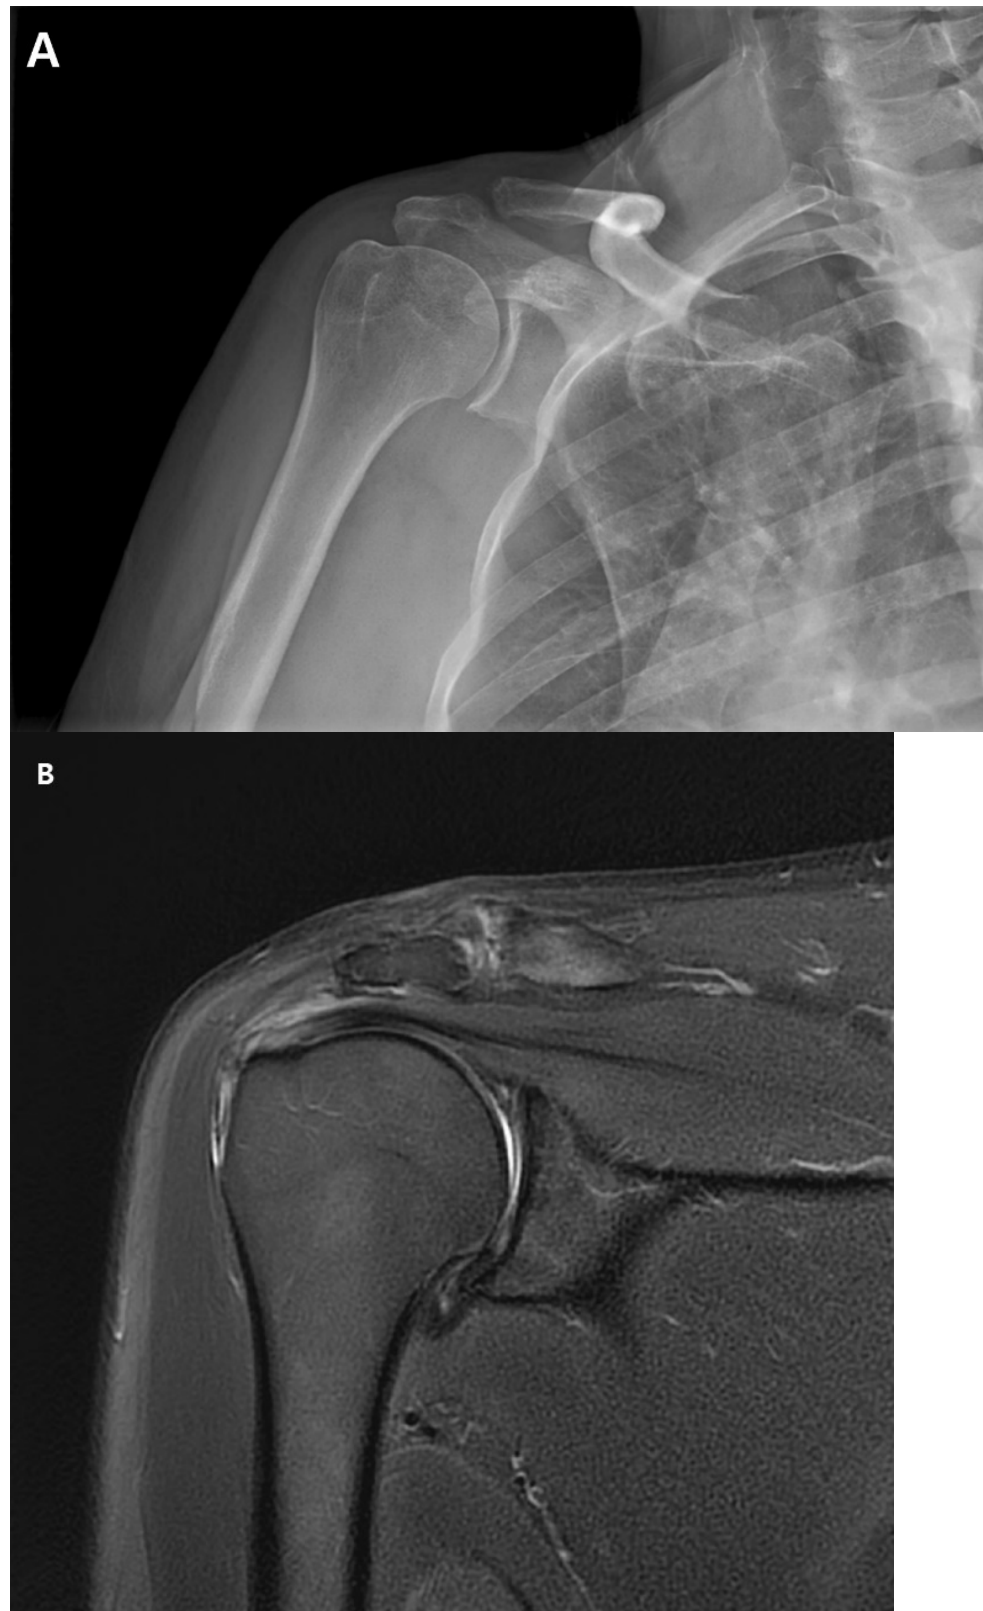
(A). Preoperative plain anteroposterior radiograph. Acromioclavicular joint alignment was acceptable with no arthritic changes. The glenohumeral joint showed adequate joint space and congruency. (B). Oblique coronal T2 fat-suppressed magnetic resonance imaging (MRI). MRI of the right shoulder showed a thickened axillary pouch with normal hypointense joint capsule. The supraspinatus tendon had high signal variation with intact continuity.
